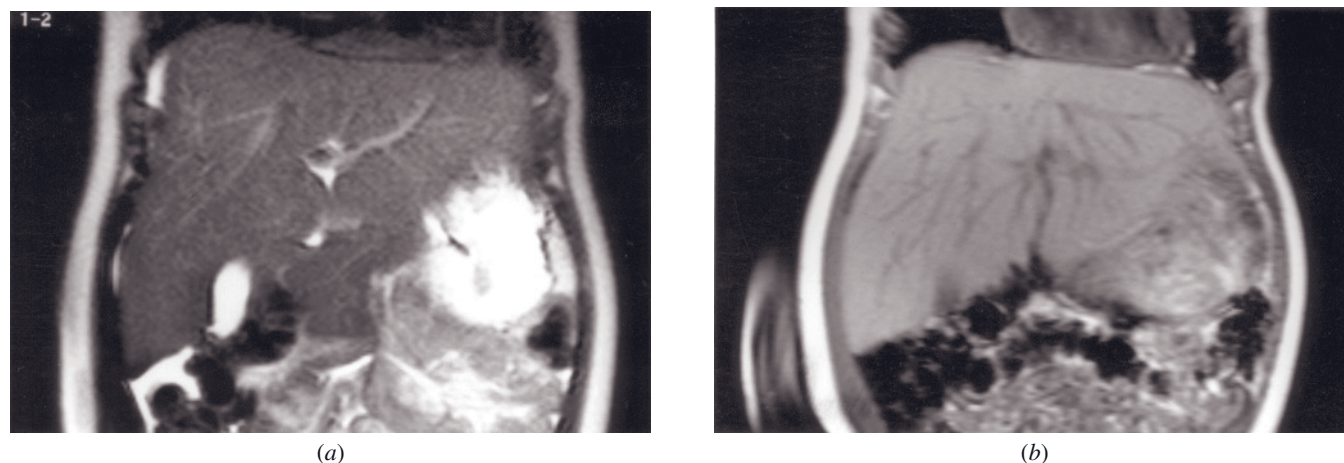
Storage disease. Coronal T2-weighted SS-ETSE (a) and SGE (b) images in a patient who has a history of mucopolysaccharidosis. Note enlargement of the liver well demonstrated on coronal images.
